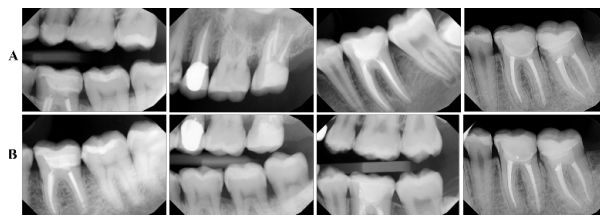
Radiographic image showing the follow up of the LDC endocrown.
